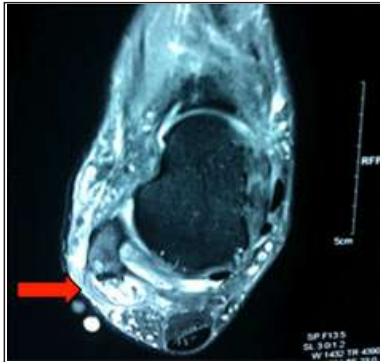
MRI imaging showing Peroneal tenosynovitis
